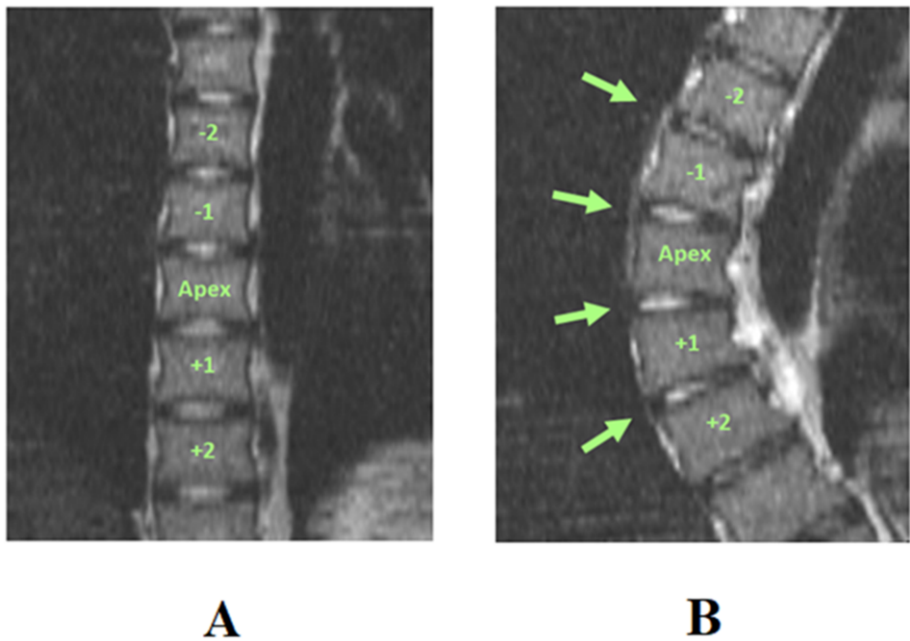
The morphological change of intervertebral discs and vertebral bodies in control (Figure 1A) and severe-AIS (Figure 1B). T2 coronal MR image shows the nucleus pulposus is central in location in control but shifted to the convexity (arrows) in AIS with a severe curve.
